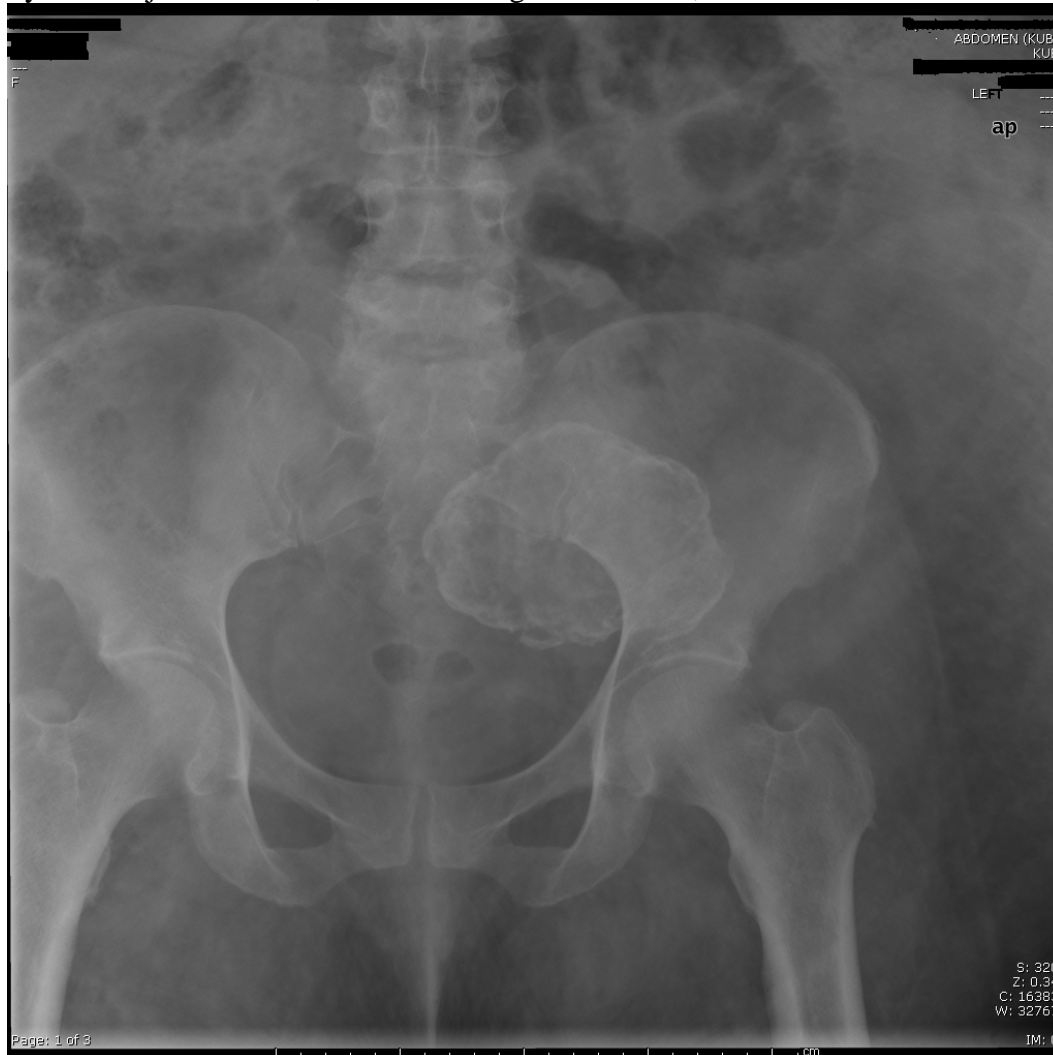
Abdominal X-ray showing a calcified lesion at the left lower quadrant of the abdomen.
